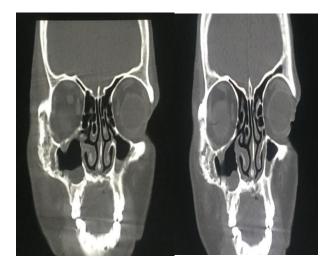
CT scan of paranasal sinuses of lytic lesion in right maxillary sinus.
